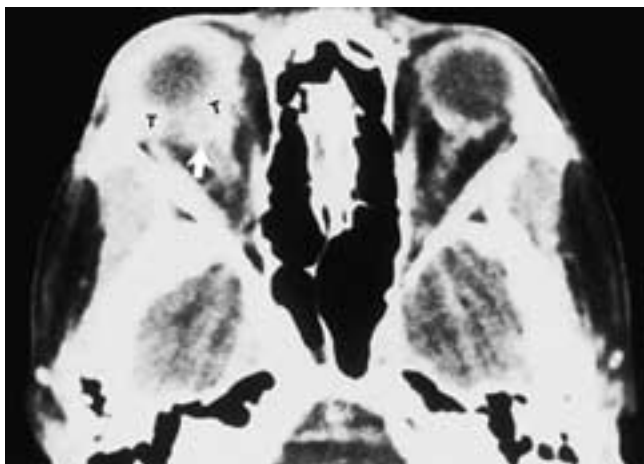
Pseudotumor: periscleritis/perineuritis. Postcontrast axial CT scan shows diffuse thickening of the scleral coat with inflammatory infiltration into Tenon's space (T) and perineuritis (arrow).
